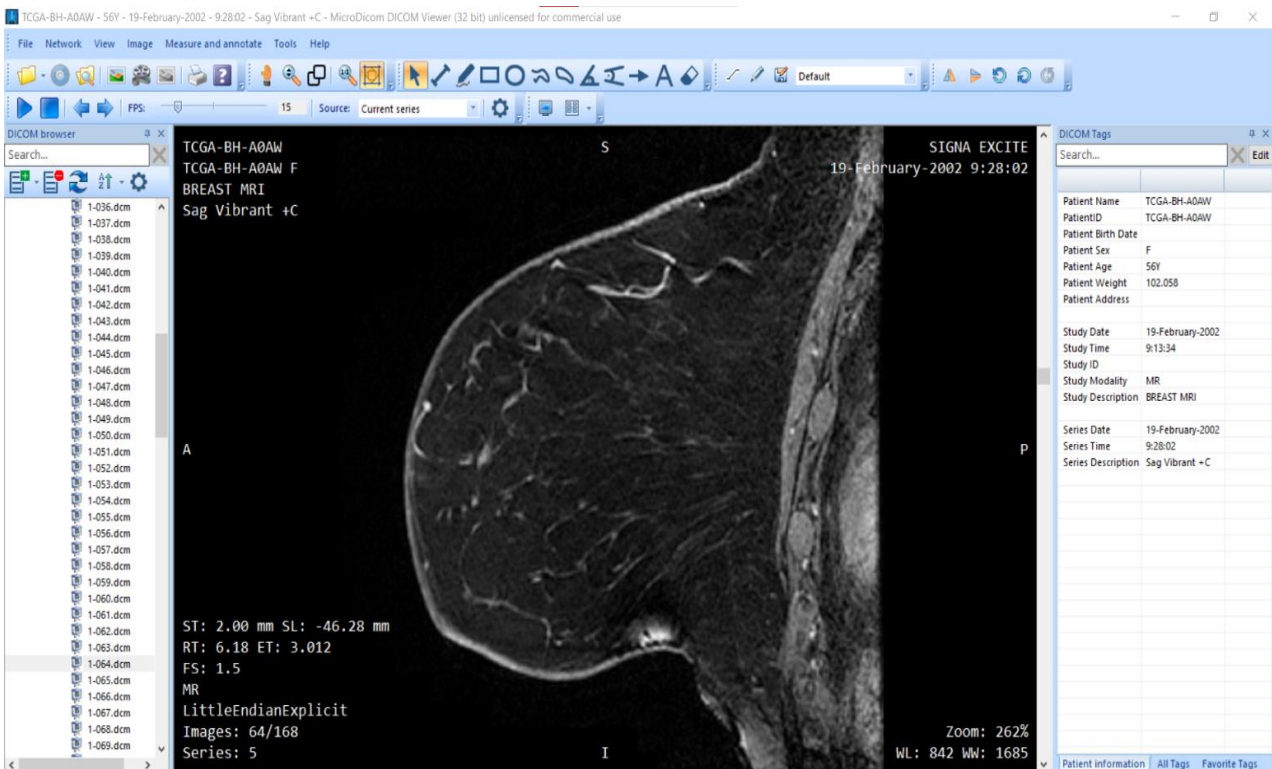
An example of one slice of the selected sagittal vibrant breast MRI
